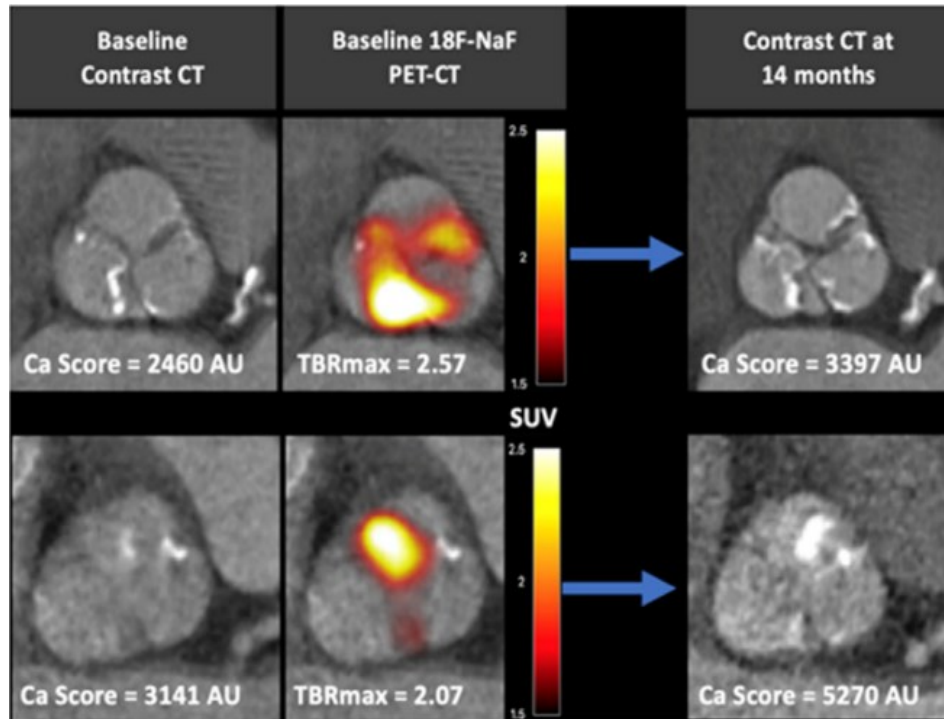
Prediction of calcium deposition in native aortic valves. Progressive aortic valve calcium score and new macroscopic calcium deposits in a similar distribution to that of baseline PET uptake. TBRmax: maximum aortic valve max tissue-to-background ratio, SUV: standard uptake value, PET: positron emission tomography; CT: computed tomography. From Fletcher et al. J Nucl Cardiol 28(2):481-491, 2021 ⁽¹²⁴⁾.
